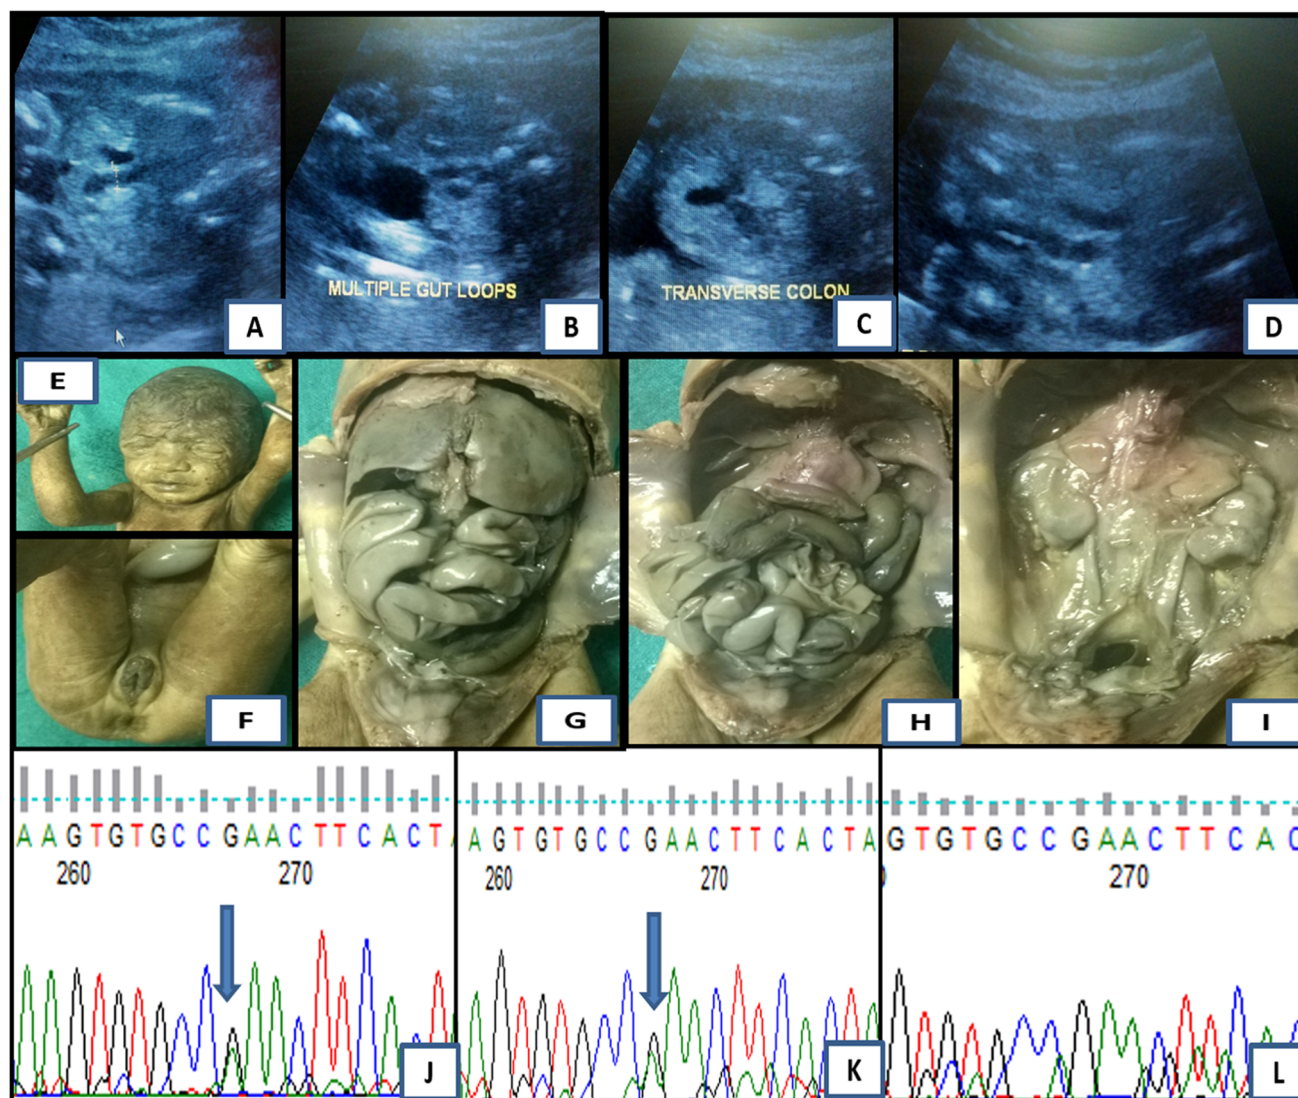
a–d Depict the ultrasound findings: a Transverse view of fetal abdomen showing dilated bowel loop with diameter measuring 5.3 mm which is more than the mean value 3.98 mm (95% CI for 24 weeks of gestation). b Transverse view of fetal abdomen with multiple dilated bowel loops. c Transverse view of fetal abdomen with dilated transverse colon. d Coronal view of fetal abdomen with dilated descending colon extending into pelvis. e–i Depict autopsy
